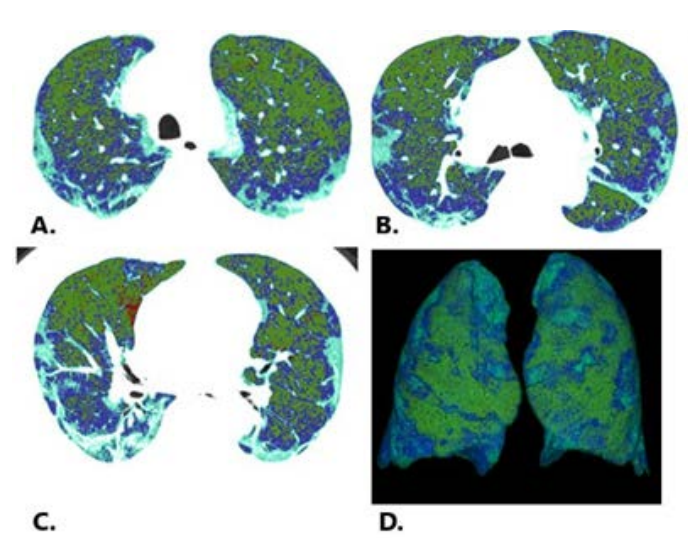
Grade 2: Automated Lung Density Color Mapping. Axial CT images obtained (A) 5 cm above the tracheal bifurcation, (B) at the level of the tracheal bifurcation, and (C) 5 cm below the tracheal bifurcation, with (D) three-dimensional volume rendering. Density-based color classification according to HU intervals: red, emphysema (-1000 to -950 HU); green, hyperinflation (-949 to -850 HU); blue, normal parenchyma (-849 to -700 HU); light blue, hypoventilation/consolidation corresponding to fibrosis-like changes (-699 to -200 HU).
